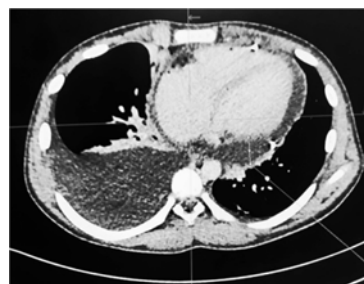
Axial CT image showing pericardial effusion.
